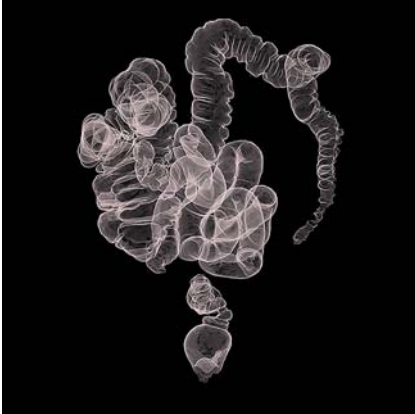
Computed tomographic colonography shows colonic stenosis in a 58-year-old man presenting with acute diarrhea and a positive fecal occult blood (FOB) test result.
